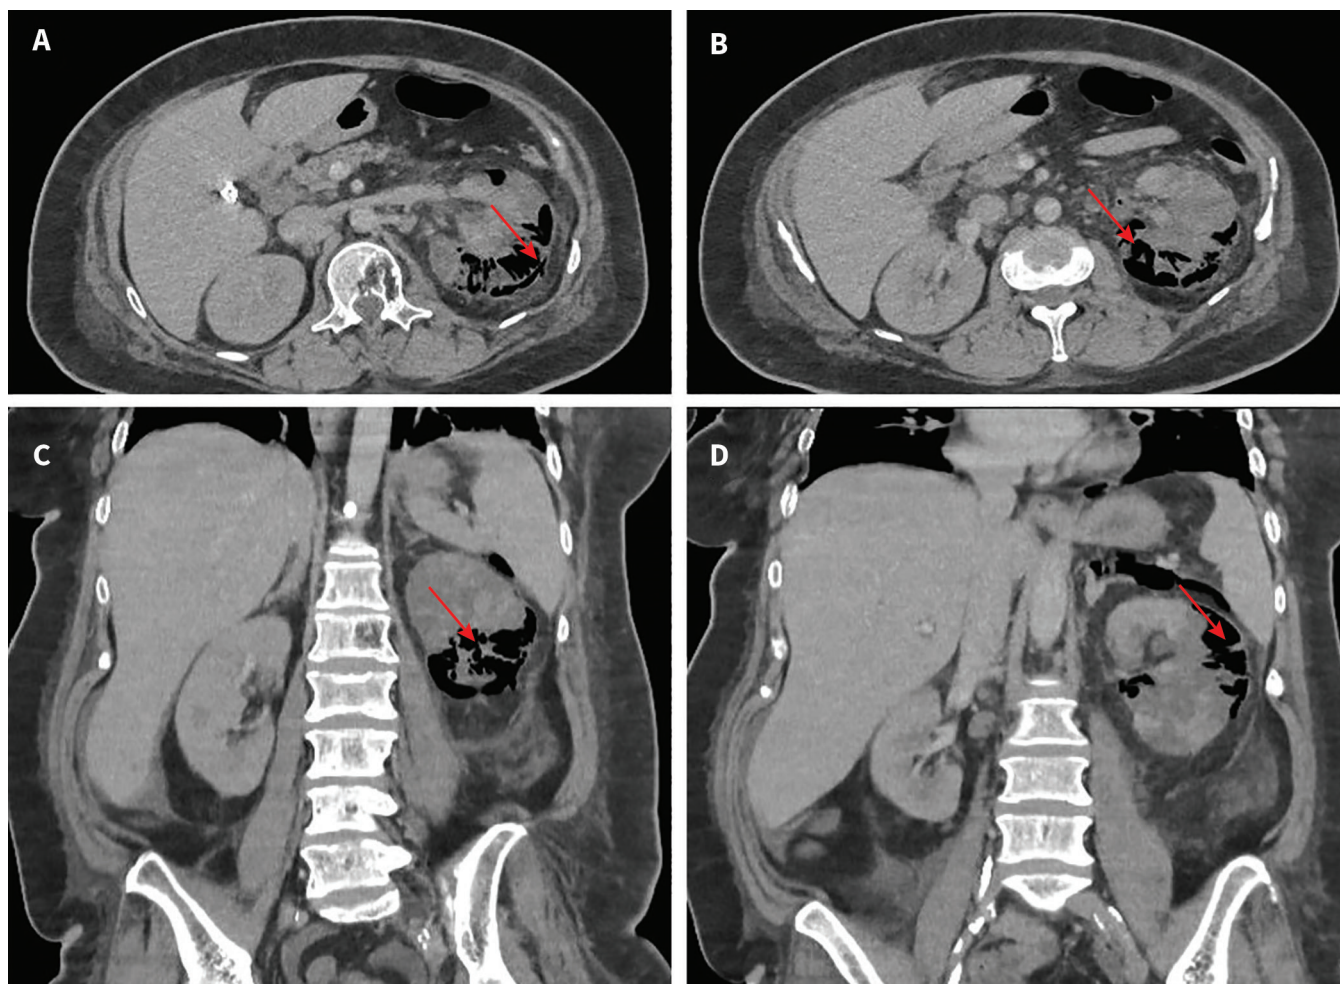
The contrast enhanced CT scan of the abdomen.
